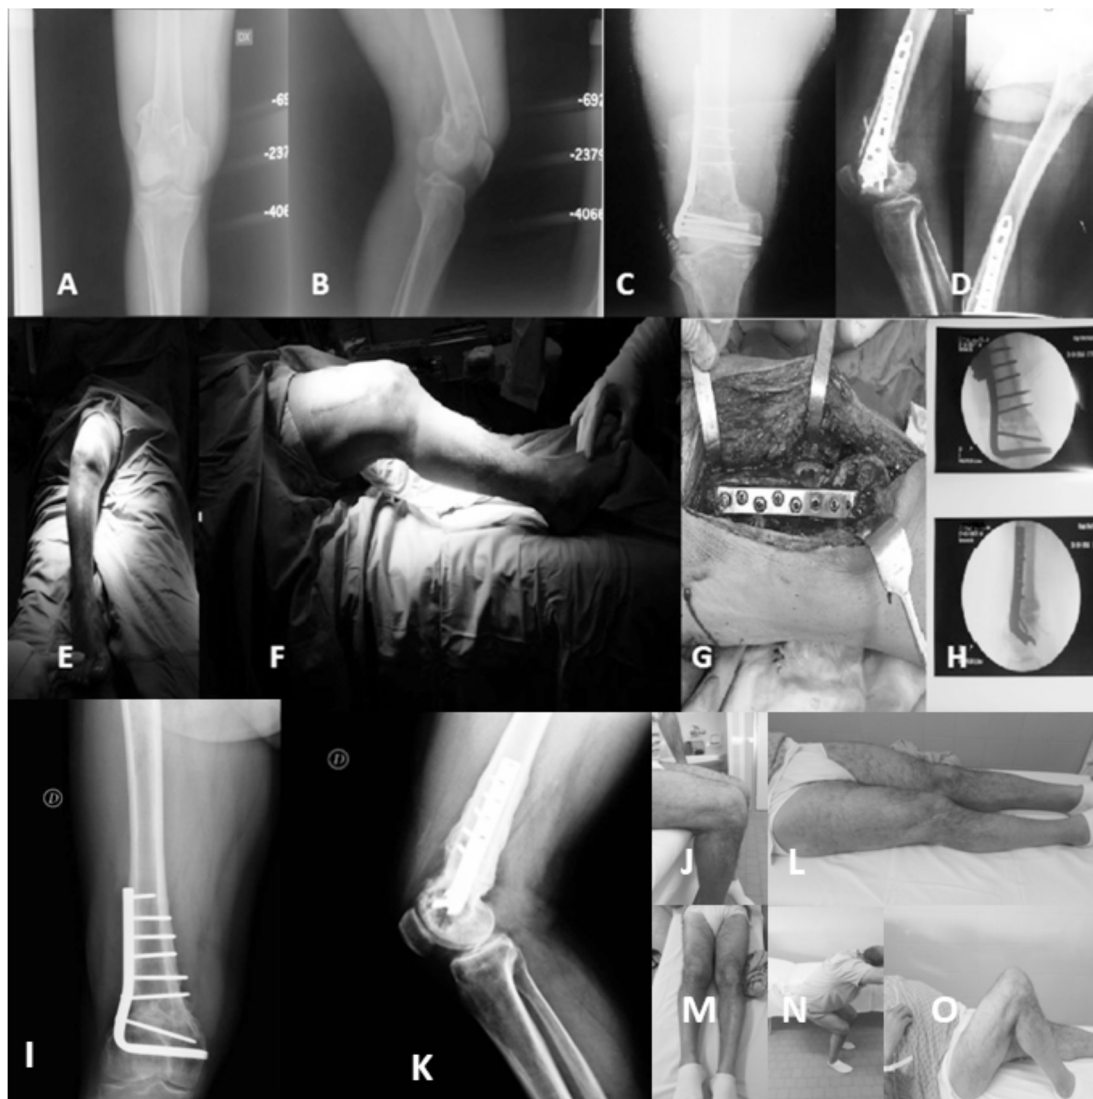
A, B) X-rays of distal femur's supra and intra condylars fracture (33.C1 according AO/OTA) in 47 years old male; C, D) fracture healing in mal union with a plate and screws (LISS) after 12 months after surgical treatment; E, F) the varus and flexion deformity of the injured knee; G) implant of plate blade system; H) X-rays of post-operative; I, K) The X-Rays control after one year from surgery show the perfect alignment and bone healing; J, L, M, N, O) the excellent clinical control after one year from the surgery (Rollo G, 2014)
